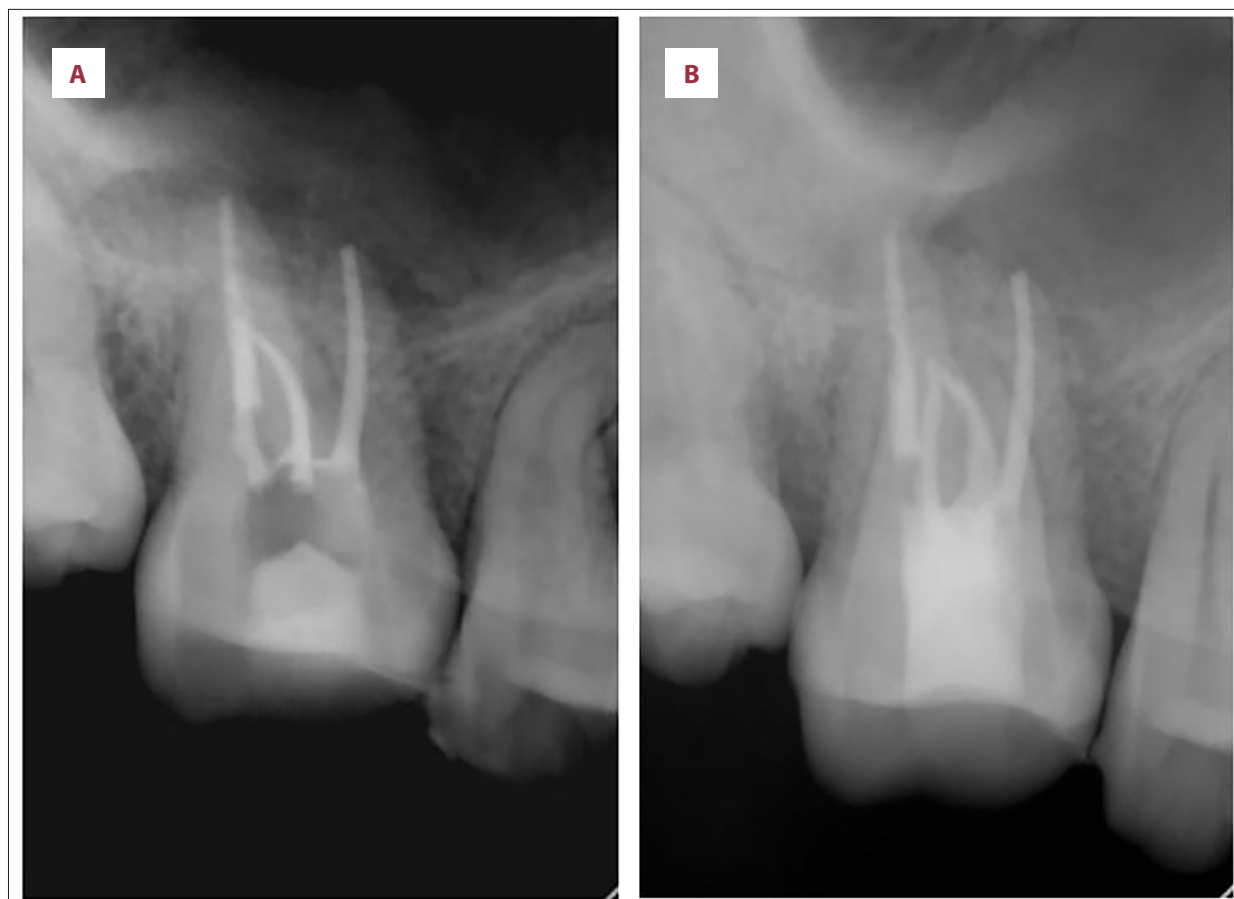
Periapical radiographs taken immediately after root canal filling (A) and after permanent coronal restoration (B).
